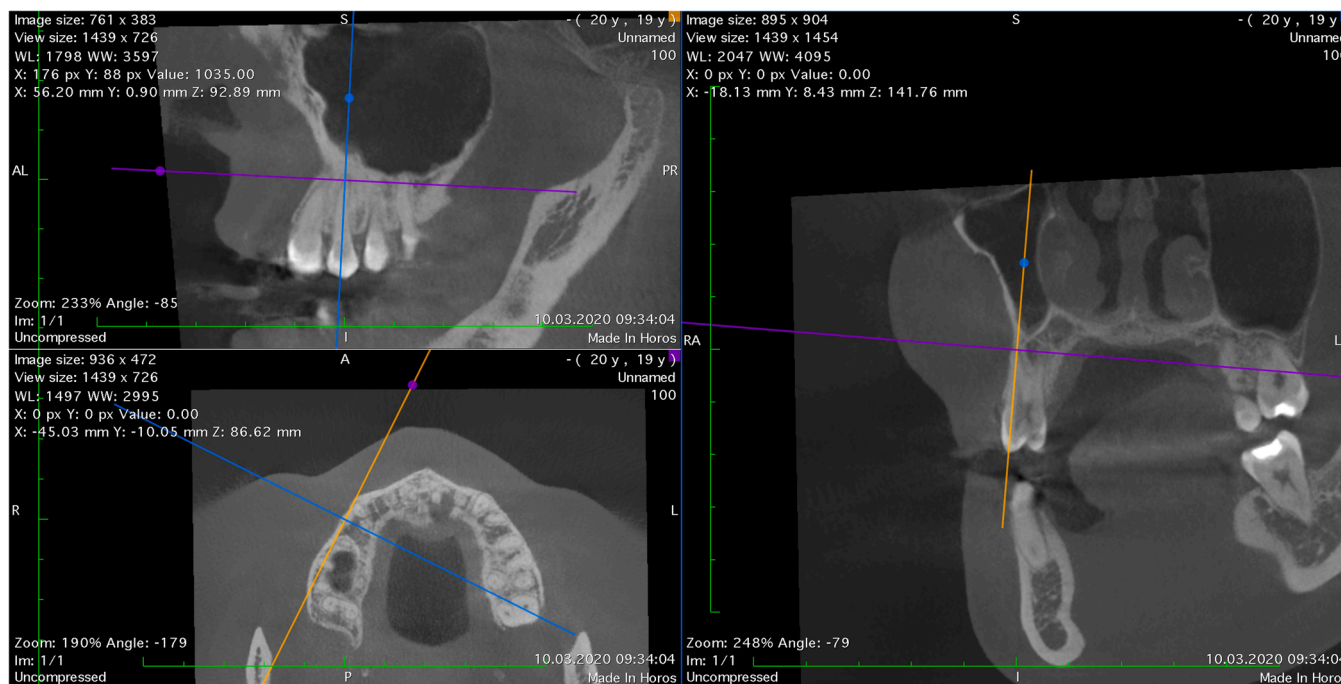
Cone beam computed tomography (CBCT) images in sagittal, coronal, and axial planes in using the axial navigation method for each premolar tooth individually.
